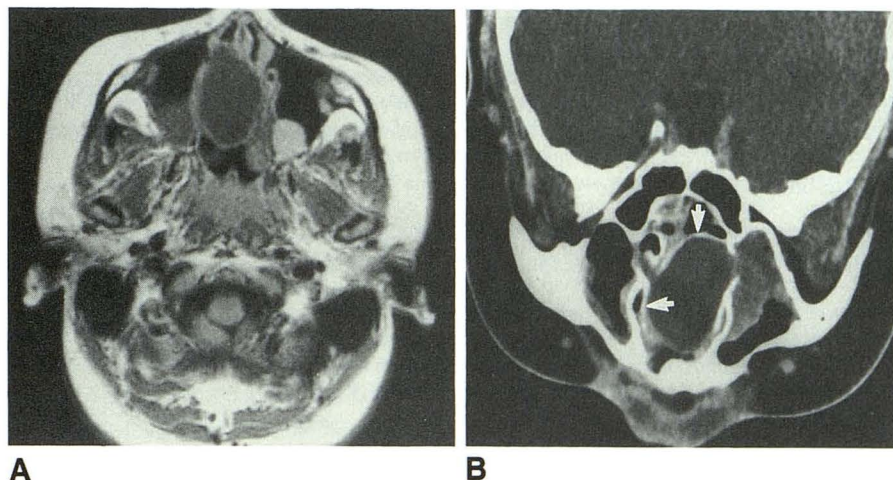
MR axial (T1-weighted 500/30) image (A) and coronal CT scan (B) of conchal mucocoele. Note that CT shows thinned bony rim (arrows), allowing easy differentiation from other soft-tissue masses of nasal fossa.
